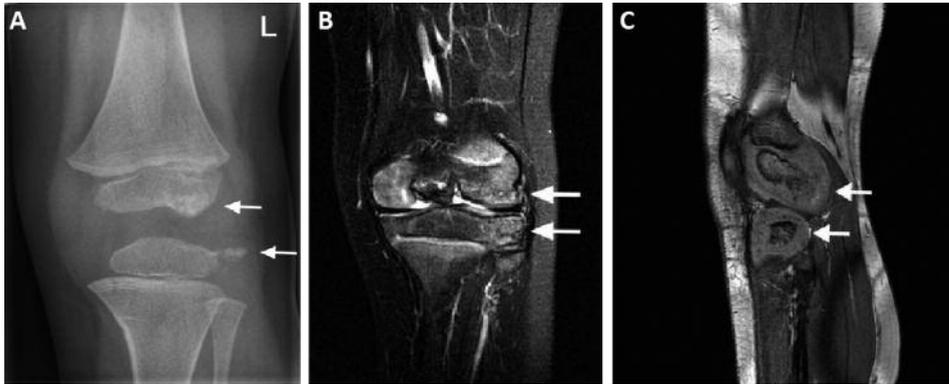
A Pre-operative anteroposterior radiograph of the left knee; B Pre-operative coronal T2W MRI scan (TR2968/ TE70); C Pre-operative sagittal BFFE CART MRI scan (TR17/TE4).
